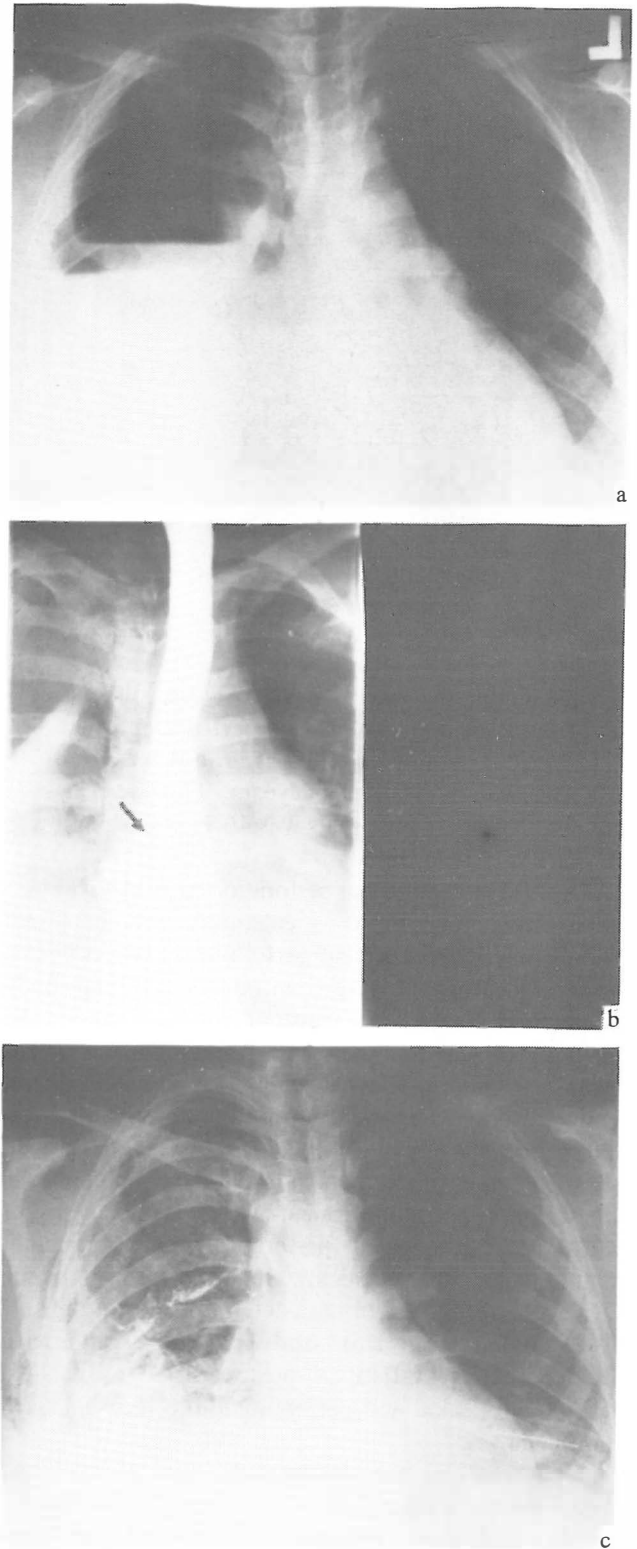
Postero-anterior chest x-ray revealing a right hydropneumothorax seen after rupture of the esophagus (a); esophagogram of same patient showing extravasation of Gastrografin in the right pleural space (b), and chest x-ray (PA) after drainage of the right pleural cavity (c).
